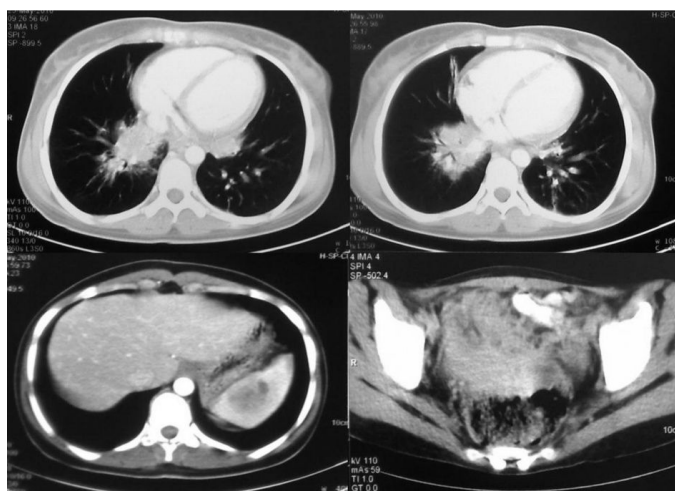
Chest and abdominopelvic CT scan with contrast revealed perihilar mass in right lung (above), hypodense lesion in spleen (left below) and heterogeneous infiltrative soft tissue density in pelvic fossa (right below).
